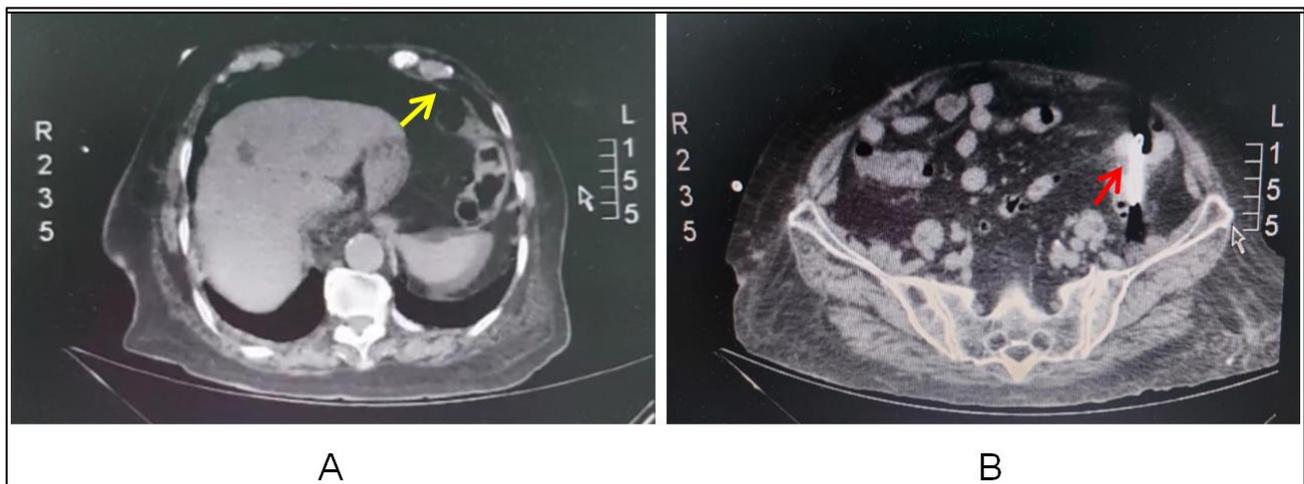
Abdominal CT at admission. A: pneumoperitoneum. B: foreign body at the transition of the descending and sigmoid colon
